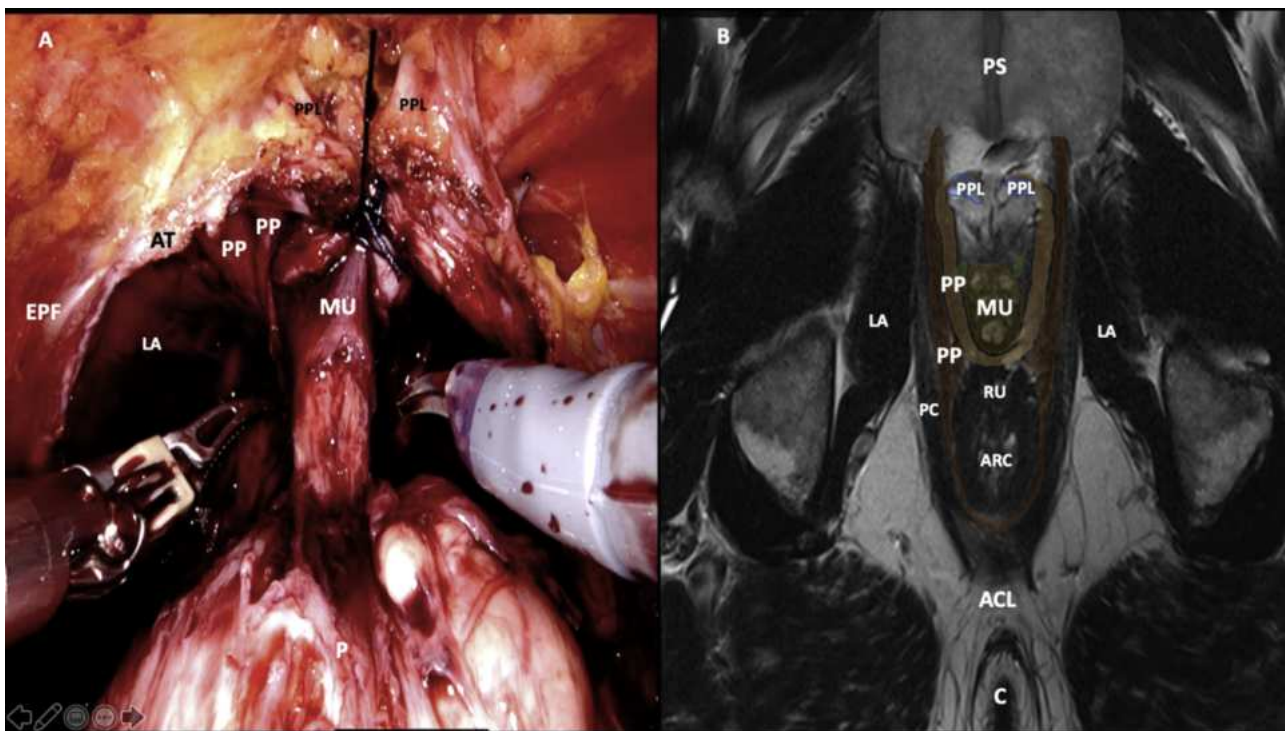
MRI and intraoperative images corresponding to section B. (A) Intraoperative image showing the membranous urethra and muscles surrounding the urethral sphincter. (B) MRI of the pelvis (cross section) corresponding to the intraoperative image. ACL=anococcygeal ligament; ARC=anorectal canal; AT=arcus tendineus; C=coccyx; EPF=endopelvic fascia; LA=levator ani; MRI=magnetic resonance imaging; MU=membranous urethra; PC=prostatic capsule; PP=puboperinealis muscle; PPL=puboprostatic ligaments; PS=pubic symphysis; RU=rectourethralis muscle.
